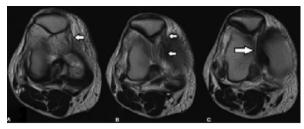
(A–C): MRI axial T2W images at the level of patellofemoral joint shows, torn medial patellofemoral ligament which is displaced internally (arrow), causing a fallacious double ACL sign
